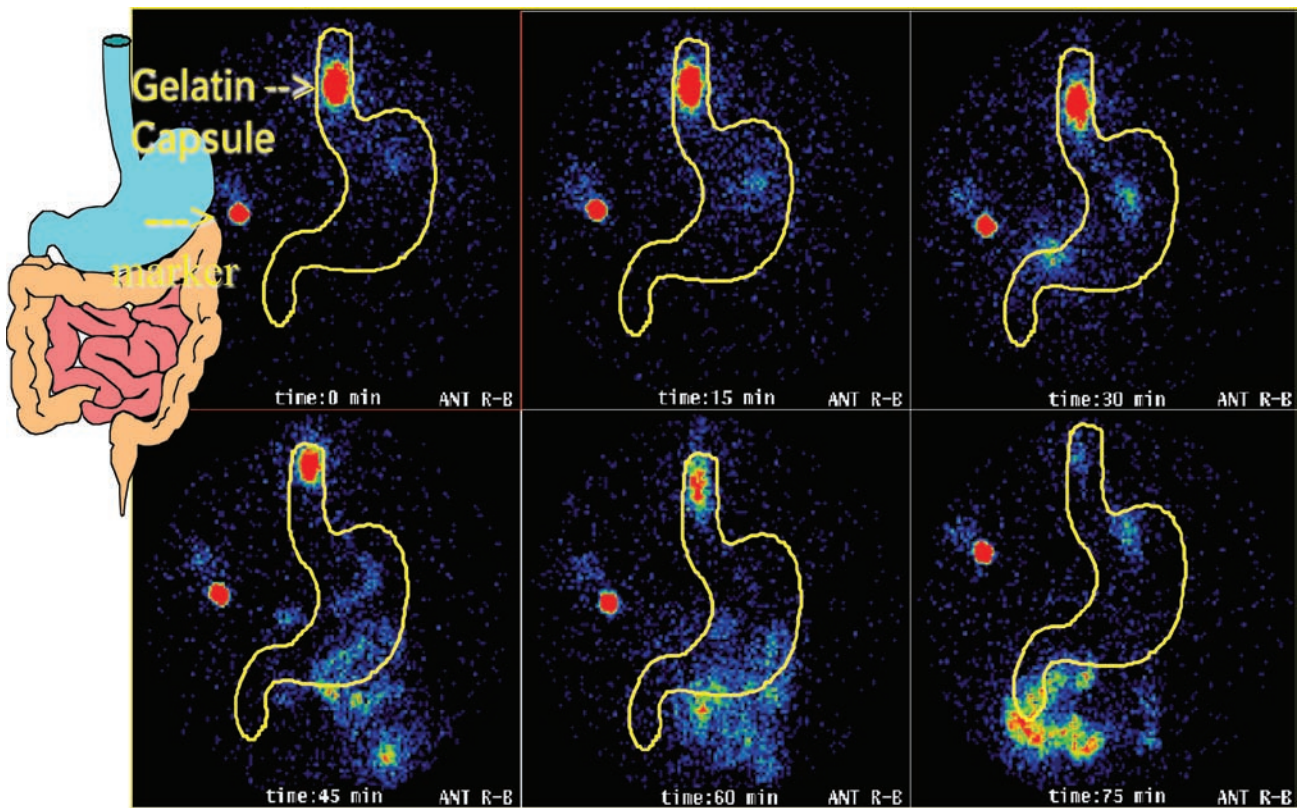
γ scintigraphy showing gelatin capsule lodged in the lower oesophagus for 60 minutes after ingestion.
